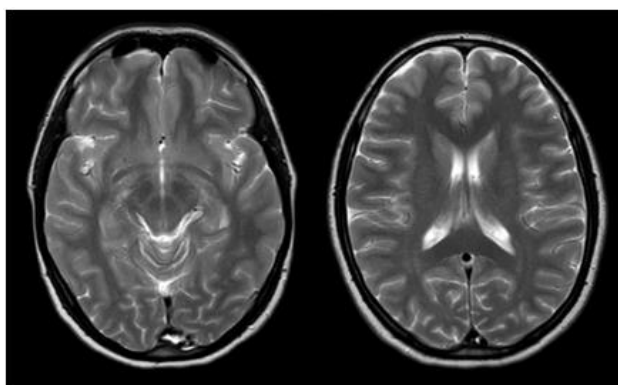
MRI of the brain showing CVS
